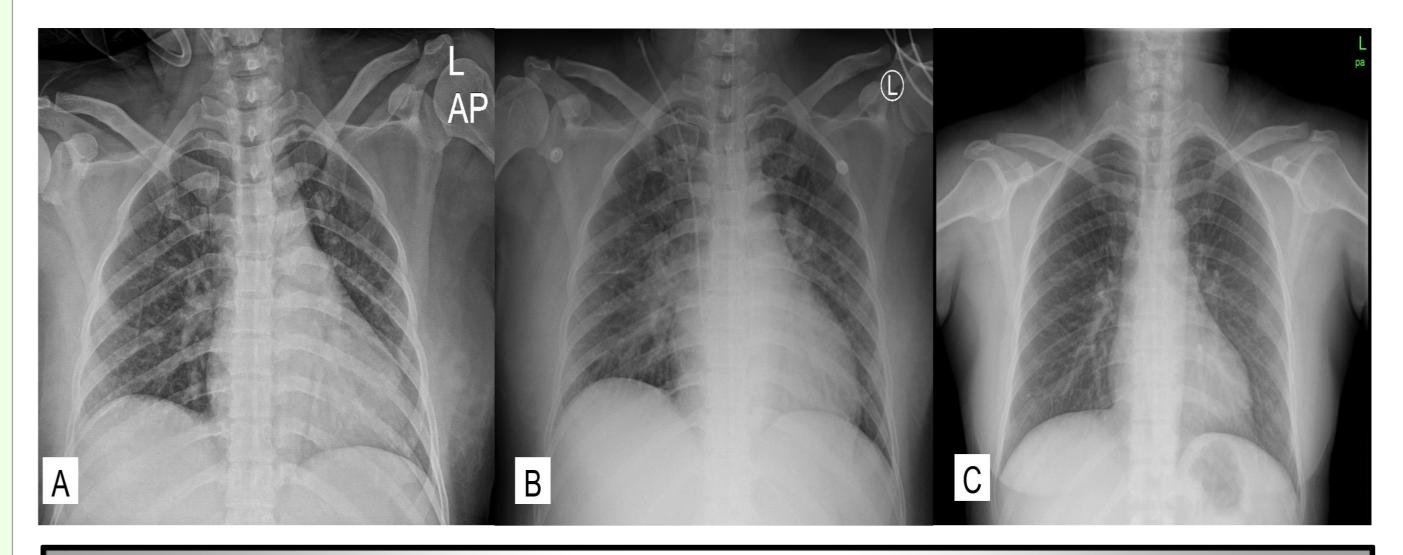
(A) Preoperative chest AP shows no active lung lesion. (B) Chest X-ray on postoperative day 2 shows aggravated consolidation in both lungs. The patient was treated with an antibiotics regimen based on pneumonia. (C) After 5 days, there was a remarkable improvement in the chest X-ray.
